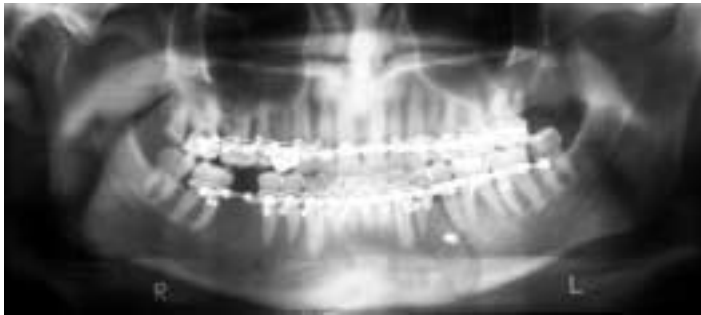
Postoperative panoramic radiograph showing an oblique isolated mandibular body fracture treated with a single 2.0-mm lag screw combined with a solid arch bar.
